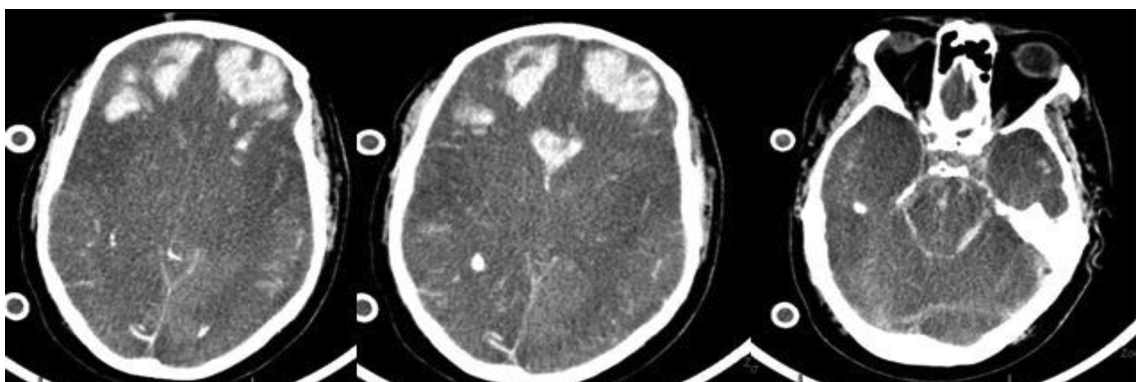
Last follow up CT brain which showed massive multiple ICH with increased ventricular compression, increased IVH, increased SAH and increased the inferior displacement of the cerebellar tonsils (herniation).
